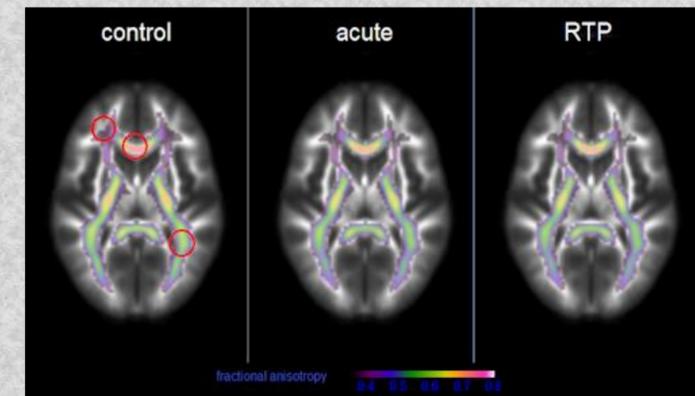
MR images show mean fractional anisotropy in white matter for control subjects compared with concussed athletes after their injury (acute) and when they were clinically cleared to return to play (RTP). Red circles indicate areas of significant concussion effects.³
